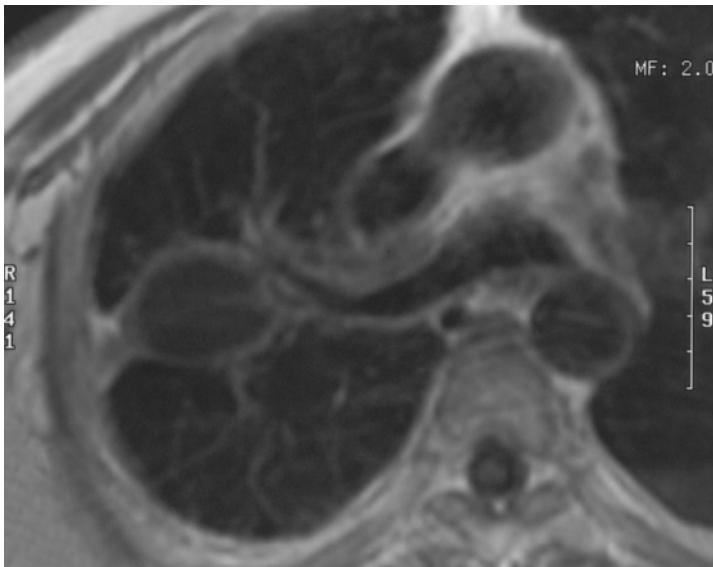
T1-weighted image of massive fibrosis with dust deposit. On T1-weighted images the dependent dust deposit appears as a signal void, while the mucus fluid above it appears hypointense.
